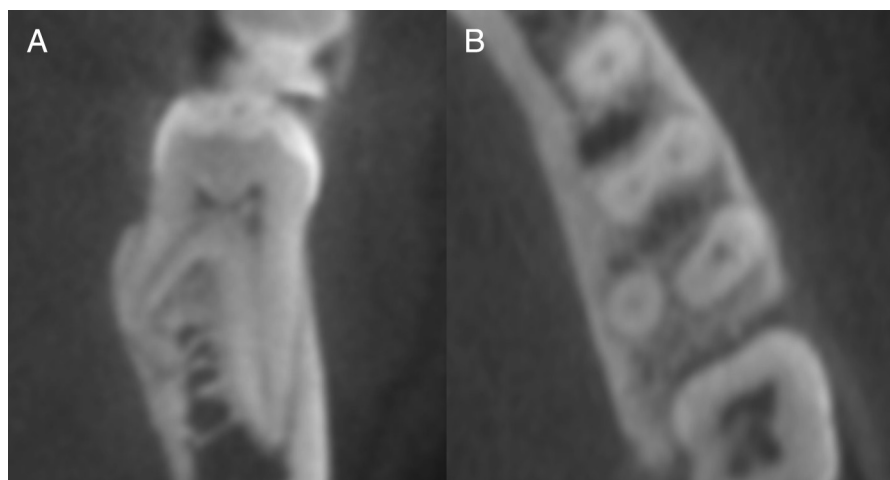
CBCT images of a first mandibular molar with a radix entomolaris: (A) cross-sectional slice and (B) axial slice.
